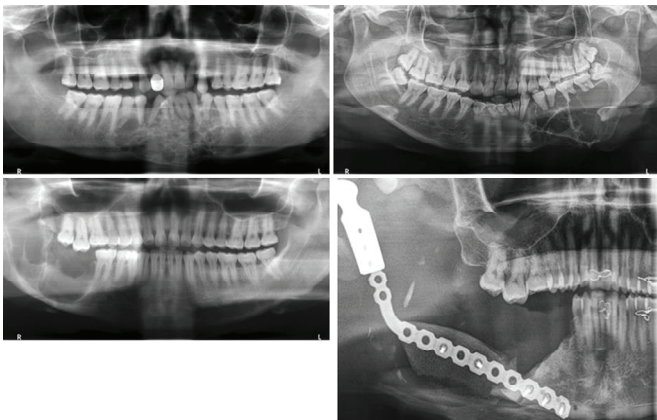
Orthopantomograms showing unicystic ameloblastoma of the anterior mandible (top left), multicystic ameloblastoma of the left posterior mandible (top right), recurrent ameloblastoma of the right posterior mandible (bottom left), and reconstruction of mandibular continuity defect using reconstruction plate, alloplastic condylar prosthesis and iliac crest bone graft secondary to resection of ameloblastoma of the right posterior mandible (bottom right)
